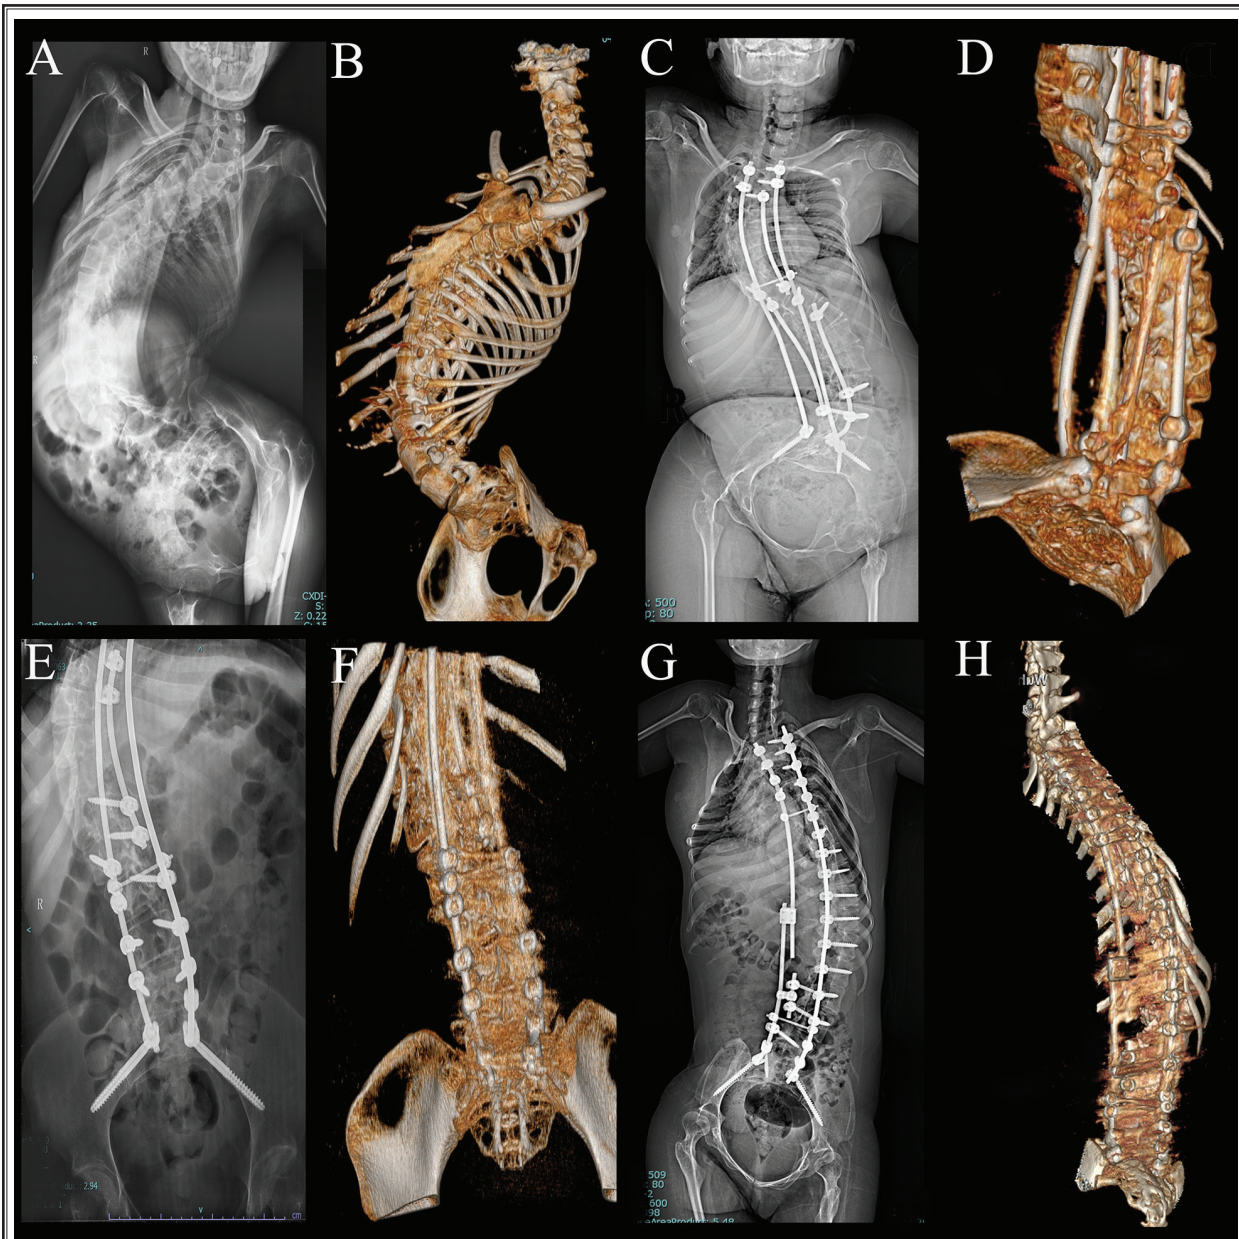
Spine x-ray and 3D CT reconstructions of adult patients with spinal muscular atrophy (A, B). X-ray and the corresponding 3D CT of spine images of one patient show severe scoliosis (C-H). X-ray and corresponding 3D CT of spine images of additional 3 patients demonstrate severe scoliosis together with spinal hardware following corrective surgery. These complex spinal anatomies significantly hinder traditional lumbar puncture techniques.
